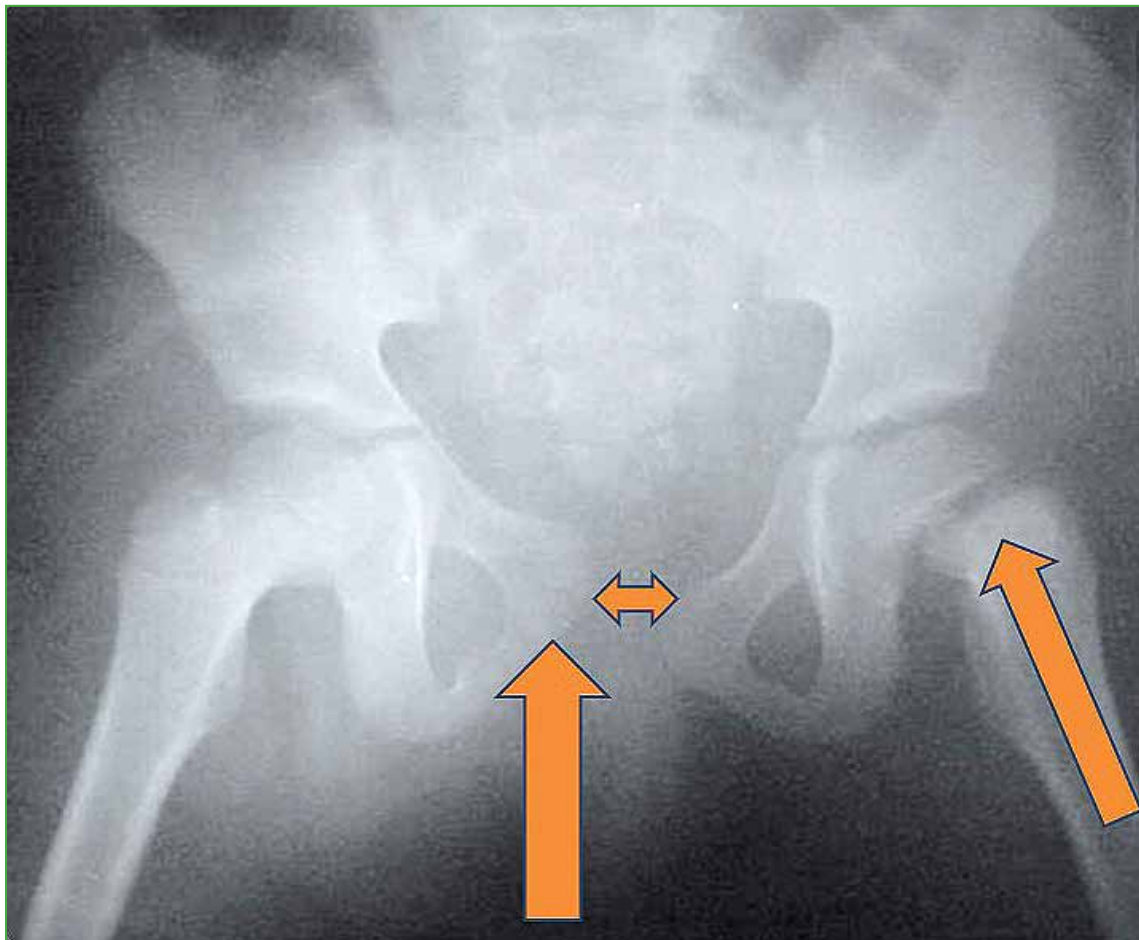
Anteroposterior pelvic radiograph. Each arrow indicates one of the multiple fracture displacements identified.
